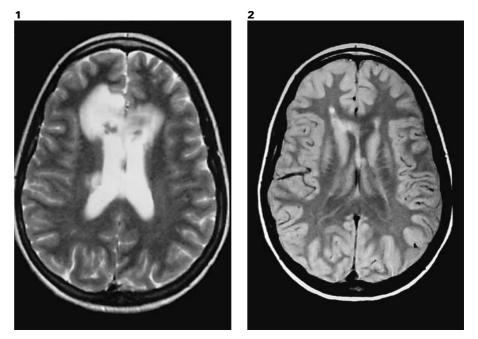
T_2 -weighted transverse MRI shows multiple space-occupying lesions in the deep white matter, adjacent to lateral ventricles. Fig. 2. Proton-density-weighted transverse MRI shows no substantial residual edema in the frontal deep white matter.
